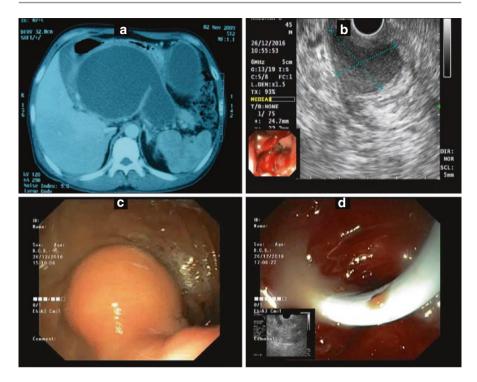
(a) Multi-detector computed tomography scan image depicting a large unilocular cystic lesion replacing the pancreas and abutting the stomach. (b) EUS image of a pseudocyst with impression along the gastric body proximally. (c) Endoscopic view which shows the bulge on the posterior wall of stomach, and (d) endoscopic view showing EUS-guided endoscopic puncture and drainage
